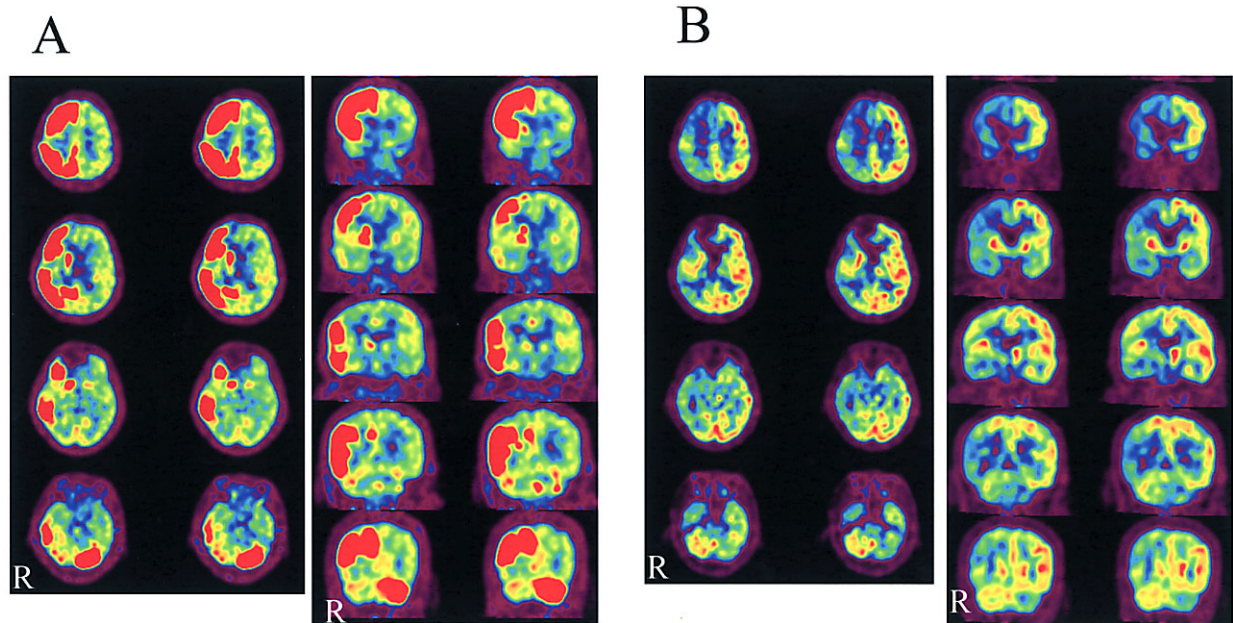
(A) Ictal [^{18}F]FDG-PET axial and coronal images obtained soon after an epilepsy attack showing diffuse glucose hypermetabolism in the right frontal, temporal and parietal lobes, right basal ganglia, and left cerebellar hemisphere. The radioactivity ratio between right/left was 3.15:1 in the frontal lobe, 3.28:1 in the parietal lobe, and 1:2.78 in the cerebellum. (B) Interictal [^{18}F]FDG-PET axial and coronal images obtained 17 days after the initial ictus showing diffuse glucose hypometabolism in these areas except for the basal ganglia. The radioactivity ratio between right/left was 0.49:1 in the frontal lobe, 0.68:1 in the parietal lobe, and 1:0.66 in the cerebellum.
